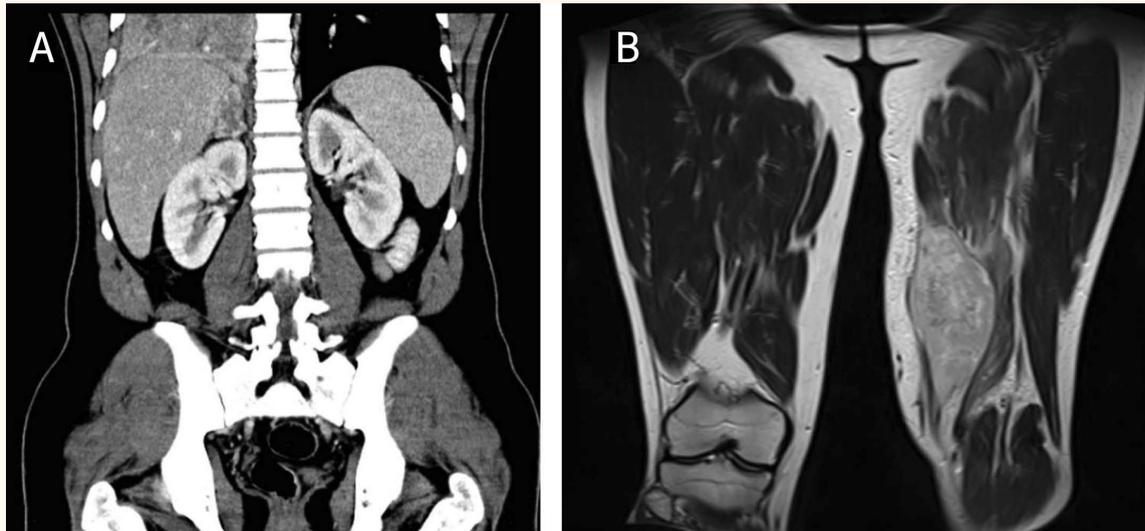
A: Computed tomography scan of the abdomen, showing an irregular mass in the right adrenal gland. B: Magnetic resonance imaging of the thigh, showing a large oval solid soft tissue mass in the medial aspect of the lower thigh.
